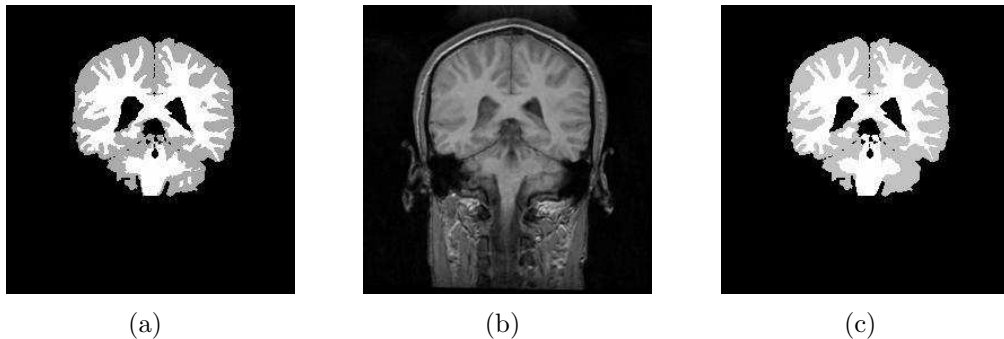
Segmentation of WM and GM tissues by our proposed method (Fig. 3.7(a)) on a real T1-weighted MRI image from ISBR (Fig. 3.7(b)) and its expert hand segmentation (Fig. 3.7(c)).
